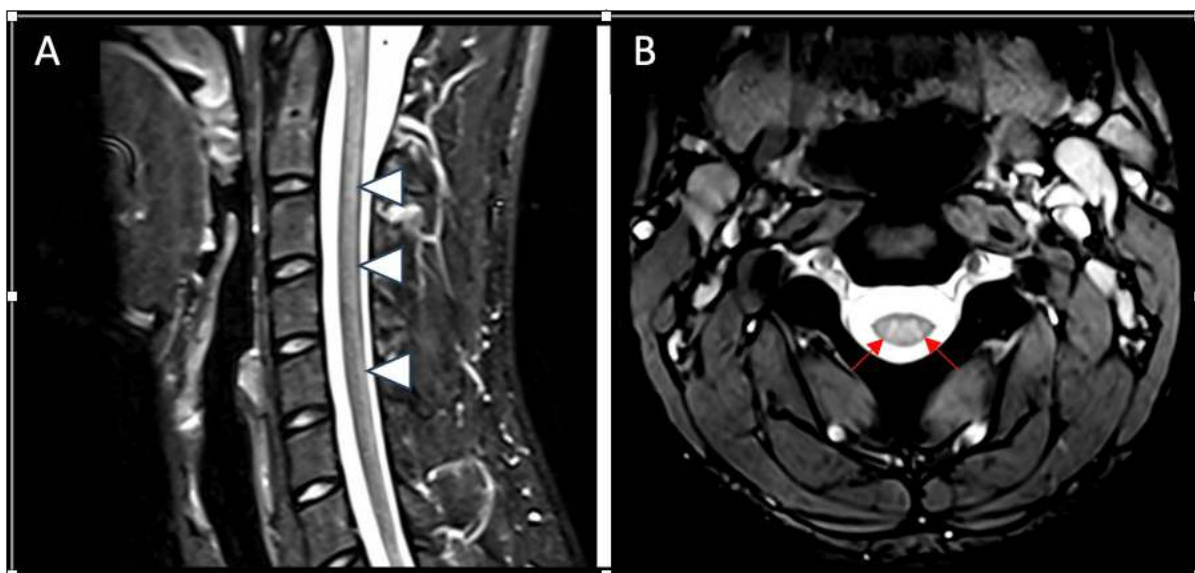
[A] Sagittal view of MRI cervical spine demonstrating subtle diffuse T2 hyperintensity along posterior cord. [B] Axial T2 weighted image of cervical spine which shows symmetrical bilateral high signal along the dorsal columns, known as the “inverted V sign.”
